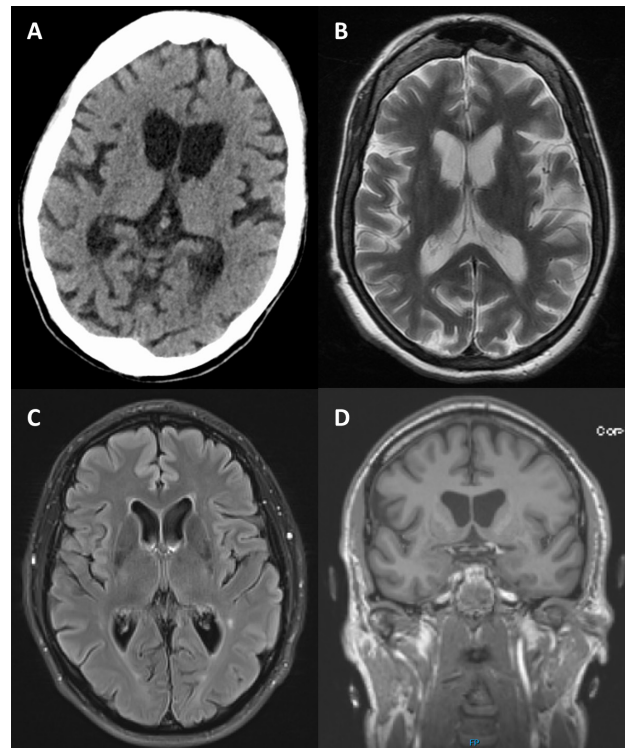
Neuroimaging in Huntington's disease. Caudate atrophy seen on axial CT (A) and T2 weighted (B) and fluid attenuated inversion recovery (FLAIR) (C and D) MRI sequences.
